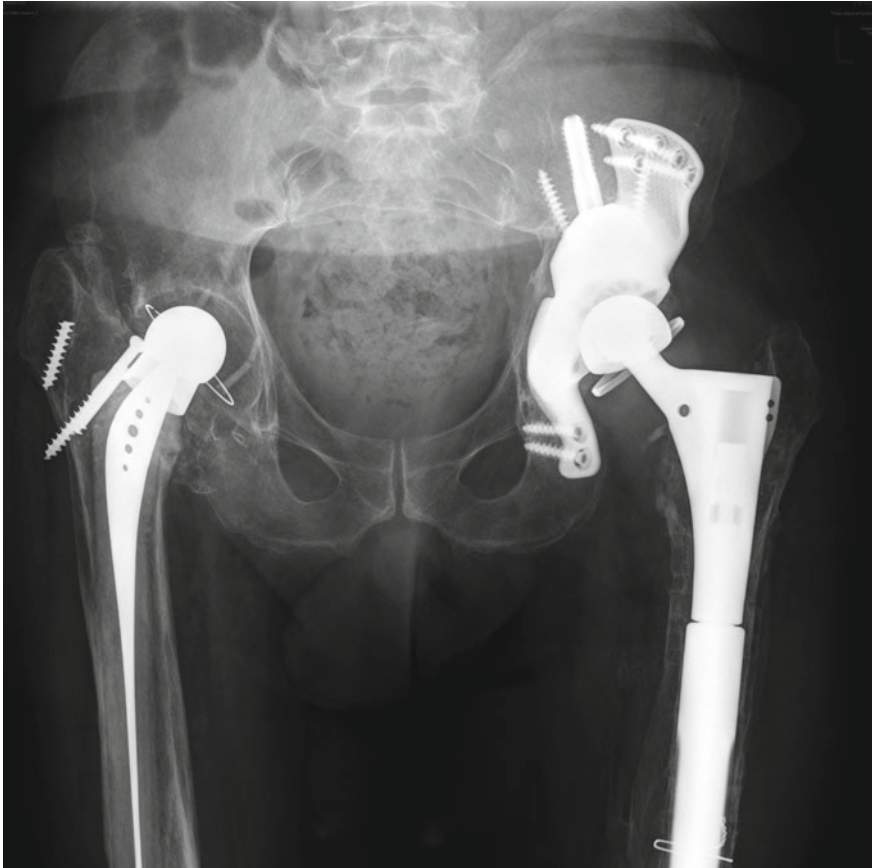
Postoperative anterior-posterior pelvic X-ray. A well-fixed custom-made acetabular component with flanges and iliac stem is seen
